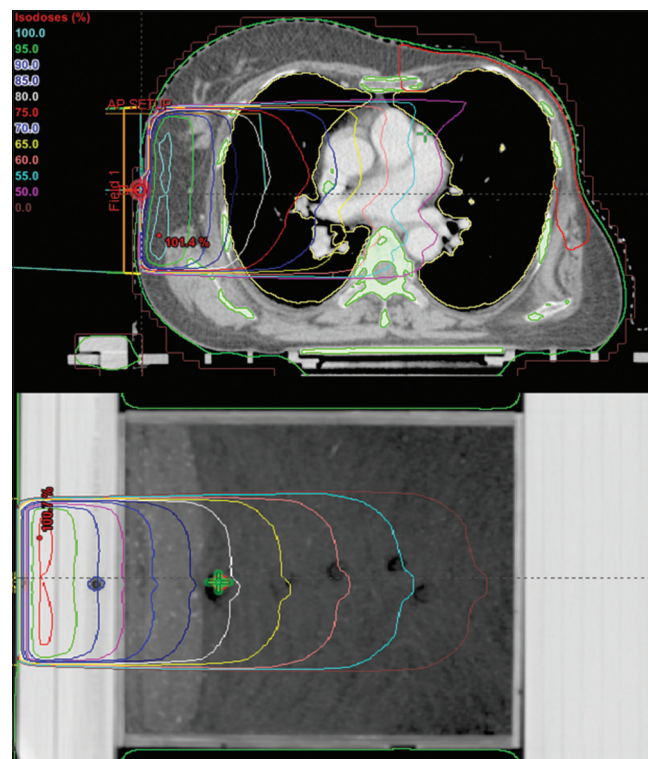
Isodose curves in CT slice of actual patient and in combination of slab-wooden dust-slab
